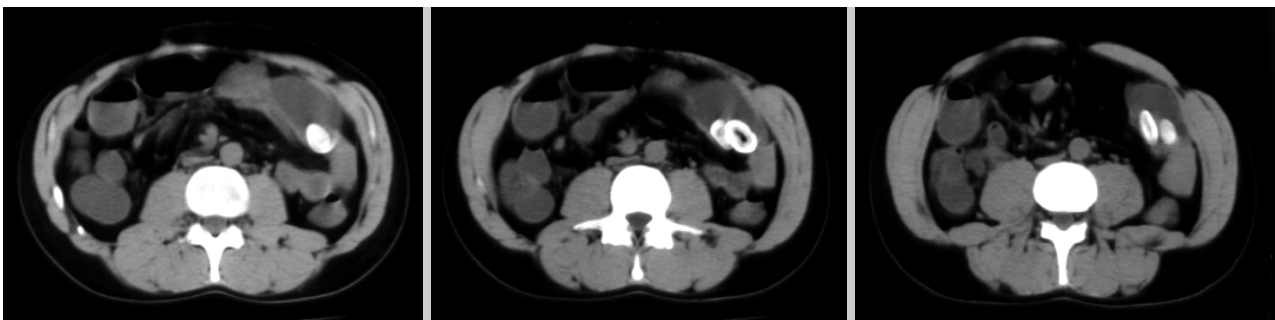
CT scans showed multiple air-fluid interfaces the distended small bowel loops and two big ectopic peripheral calcified stones with radiolucent centers in the dilated small bowel.
